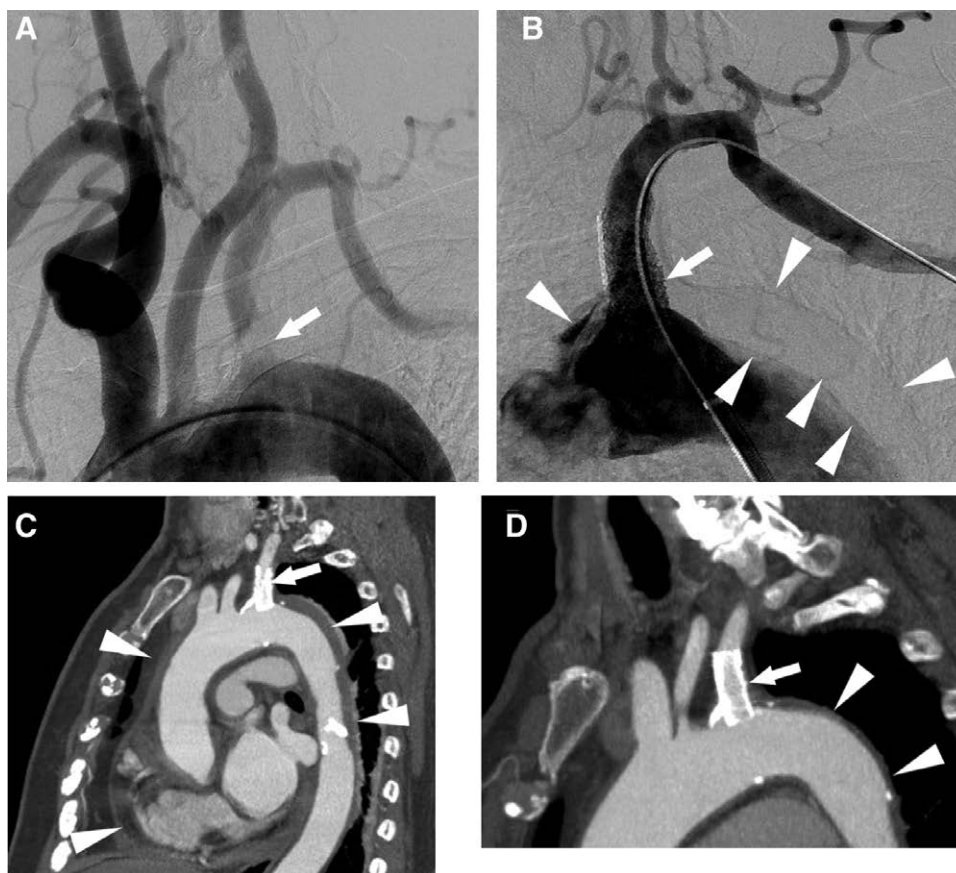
A–D, PTAS for stenosis of the left SA complicated by type A aortic dissection and hemopericardium. A 72-year-old female was admitted for dizziness due to vertebrobasilar insufficiency from 85% stenosis of the left SA (A, arrow). Just as we deployed a 9×25 mm balloon-expandable Express LD stent in the orifice of the left SA (B, arrow), the patient complained of chest tightness and temporary atrial fibrillation. The control angiogram showed aortic dissection in the ascending and descending aorta (B, arrowheads). As the symptoms persisted, she underwent contrast-enhanced CT of the chest the next day, which revealed a type A aortic dissection and hemopericardium (C, arrowheads). Follow-up CTA of the neck 1 month later showed obliteration of the aortic dissection (D, arrowheads). Note good localization of the stent (C & D, arrows). CTA = computed tomography angiography; PTAS = percutaneous transluminal angioplasty and stenting; SA = subclavian artery.
